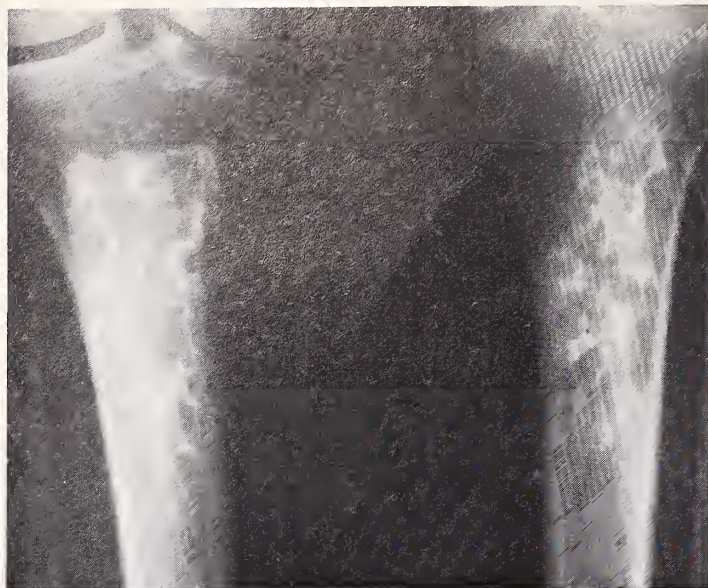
Roentgenograms of patient's knees. Obtained under weight-bearing conditions. Top: View showing full extent of lesions. Bottom: View showing details of joint spaces.
